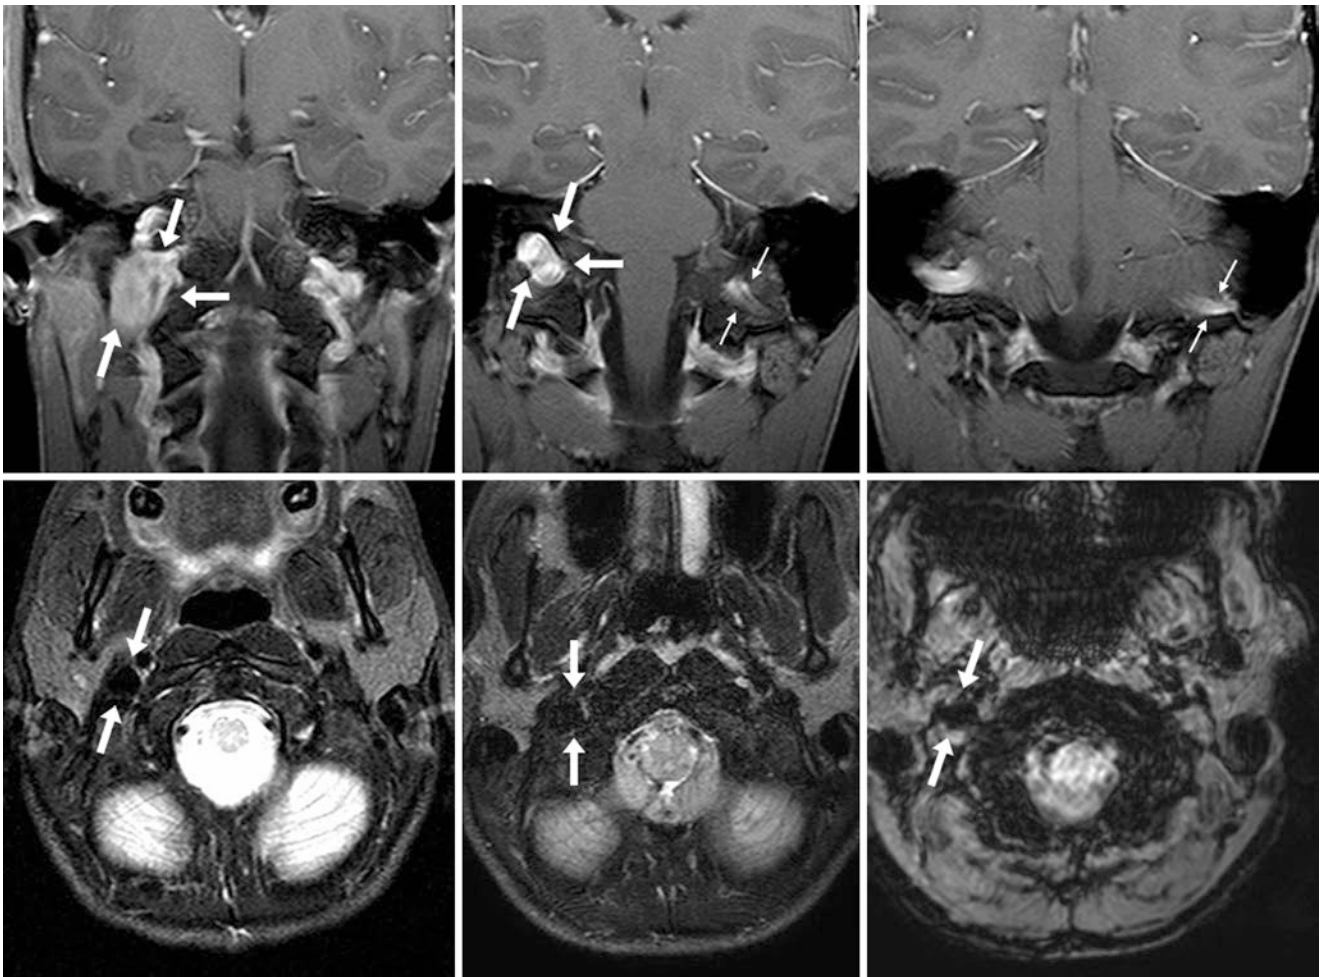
Top row:* 23-year-old with a prominent right jugular bulb (outlined by arrows) on postcontrast coronal T1WIs MRI. *Bottom row:* Axial T2WI (left), FLAIR (middle), and SWI (right) depict right IJV flow voids. Note asymmetry in the size of the dural sinuses, where the right sigmoid sinus is larger than the hypoplastic left sigmoid sinus (thin arrows)
